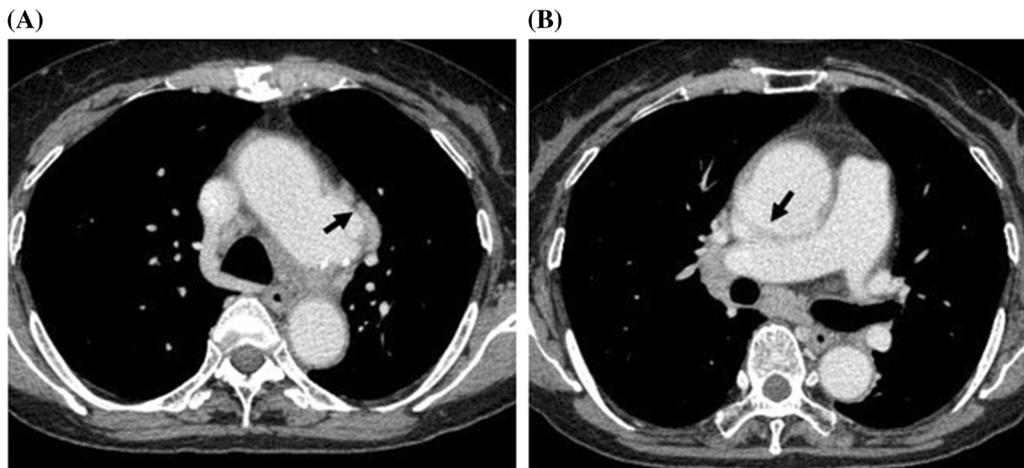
Three weeks after initial ^{18}F -FDG-PET/CT, contrast-enhanced CT images (A, B) demonstrating aneurysmal dilatation of aortic arch (arrow) and ascending aorta (arrow) corresponding to the intense ^{18}F -FDG uptake.
